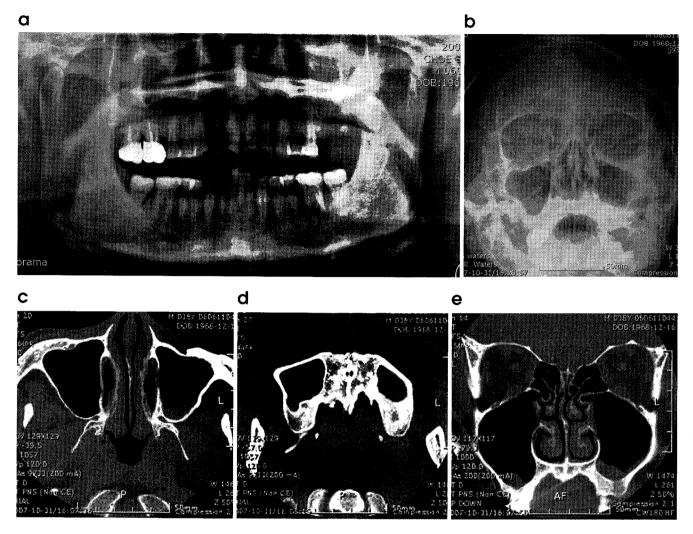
(a) Left maxillary sinus shows upper and lower radiopacity in panoramic view; (b) Mucosal thickening of lower part of left maxillary sinus in Waters' view; (c), (d), (e) Mucosal thickening of lower part of left maxillary sinus in CT.
